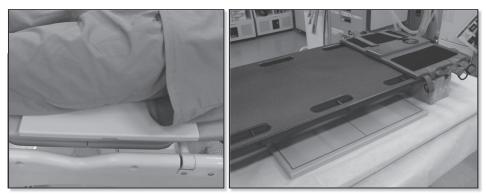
Examples of using the safety grid holder a) X-ray imaging on stretcher b) Emergency X-ray imaging
